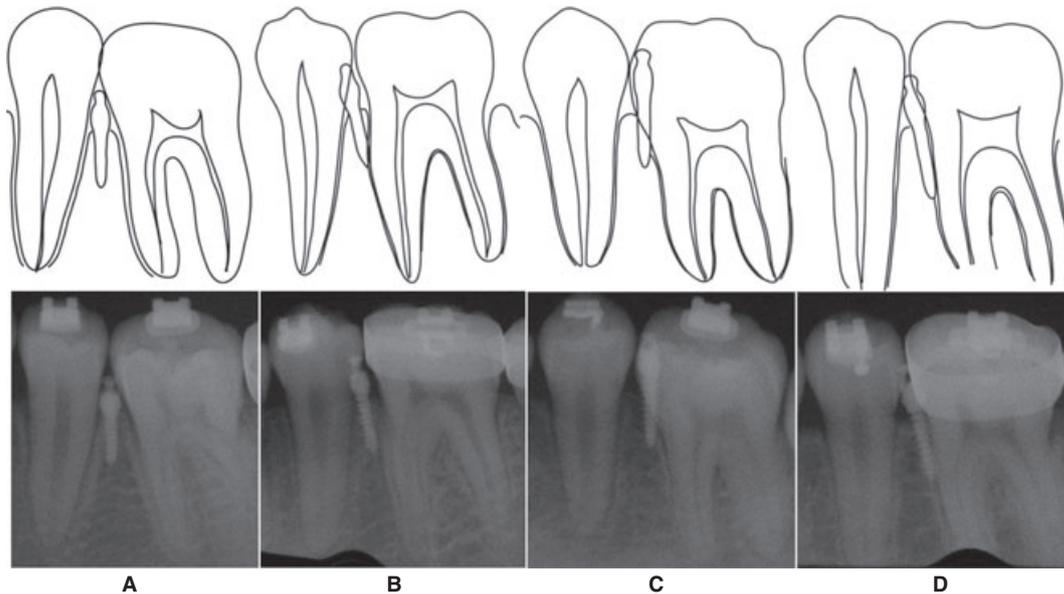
Classification of the periapical radiographs from A to D according to the proximity of the miniscrew and the root. (A) The miniscrew was completely separated from the root surface. (B) Only apex of the miniscrew was in contact with the root surface. (C) The neck at alveolar bone level or middle part of the miniscrew was in contact, and the apex was separated from the root surface. (D) The entire body of the miniscrew was in contact with the root surface.
